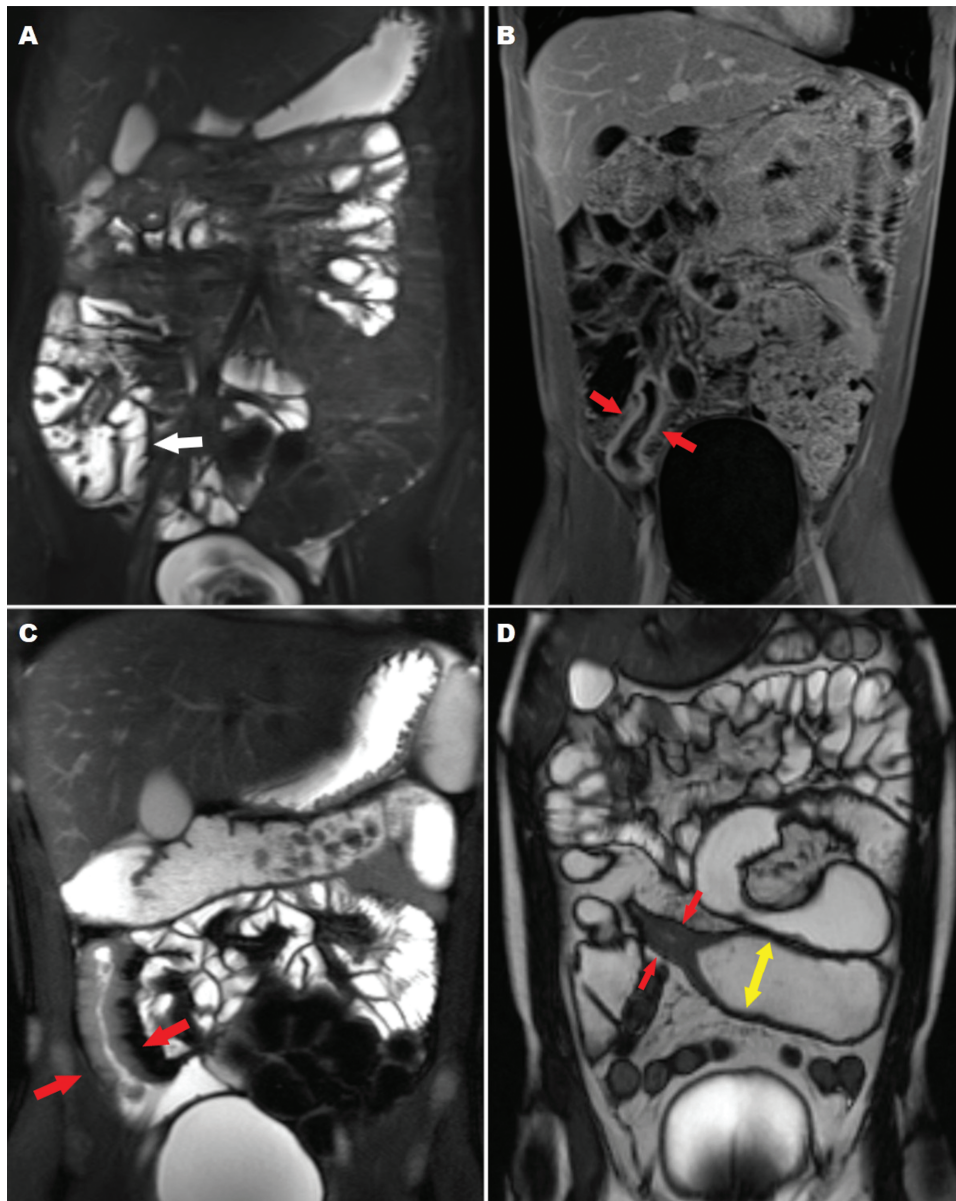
Classification of baseline ileal imaging appearances. Imaging classification of ileal CD progression was performed using AGA-SAR consensus guidelines.⁷ Representative coronal images for each of the 4 categories are shown. A, Normal TI without wall thickening (white arrow), mural edema, or LN (coronal view, single-shot fast spin-echo sequence). B, Active inflammation only of TI with mild wall thickening and postcontrast hyperenhancement (red arrows) along with adjacent mesenteric vascular engorgement, consistent with B1 inflammatory disease without LN (coronal view, contrast-enhanced T1-weighted sequence). C, LN with active inflammation (wall thickening and intramural edema) of TI (red arrows) without overt upstream dilation. The TI lumen was reduced to <50% of the more proximal small-bowel lumen. The more proximal small bowel lumen measured <3 cm (coronal view, single-shot fast spin-echo sequence). D, Strictured TI with wall thickening and LN as denoted by red arrows. The prestenotic bowel lumen was dilated and measured ≥ 3 cm (yellow arrows; coronal view, steady-state free precession sequence). TI indicates terminal ileum.
